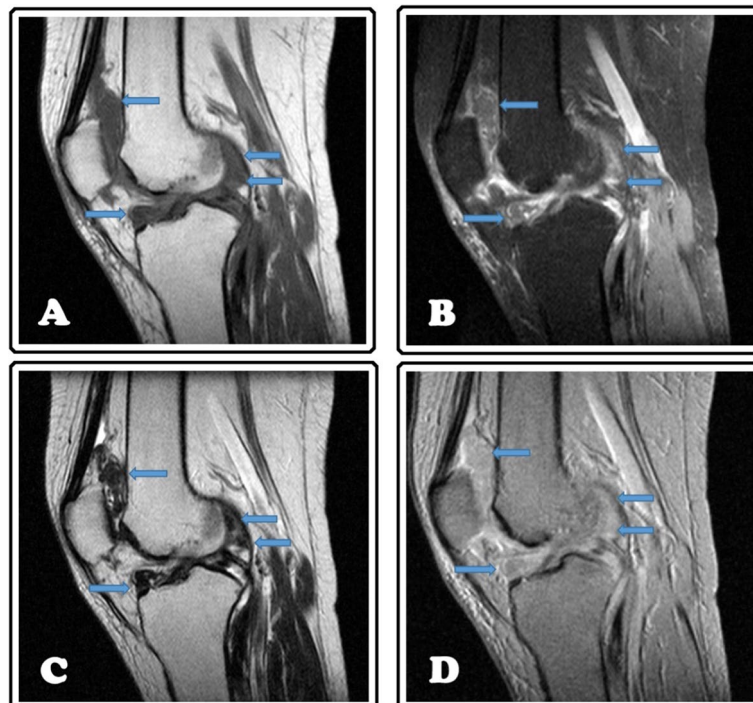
MRI pretreatment. Sagittal T1-w fast spin echo (FSE) image (A), fat-suppressed proton density (FS PD) FSE image (B), T2-w FSE image (C), and T2-w gradient recalled echo (GRE) image (D). In the articular recesses, a thickening of the synovium is identified, with multiple nodules iso-intense to the muscle in T1-w FSE and FS PD-w FSE, hypointense in T2-w FSE and without signal loss in T2-w GRE, in relation to amyloid deposits (arrows). Joint effusion is also found
